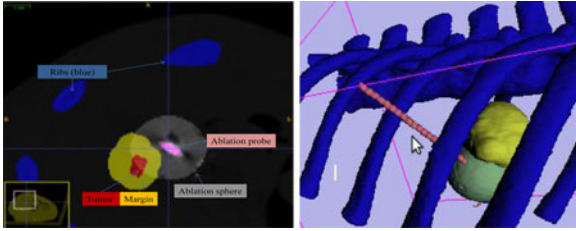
(Left) Postoperative CT scan to check the spatial relationship between the ablation probe with the region of tumor and safety margin. The virtual ablation sphere is generated via image processing centered at the probe tip and then overlaid onto the postoperative CT scan. The distance of delivered probe to tumor surface is approximately 5 mm. (Right) Postoperative evaluation on the second accomplished RFA. Yellow color represents the tumor surrounded by safety margin and the sphere denotes the virtual ablation. (Refer to the web version of this paper for the color figure.)
